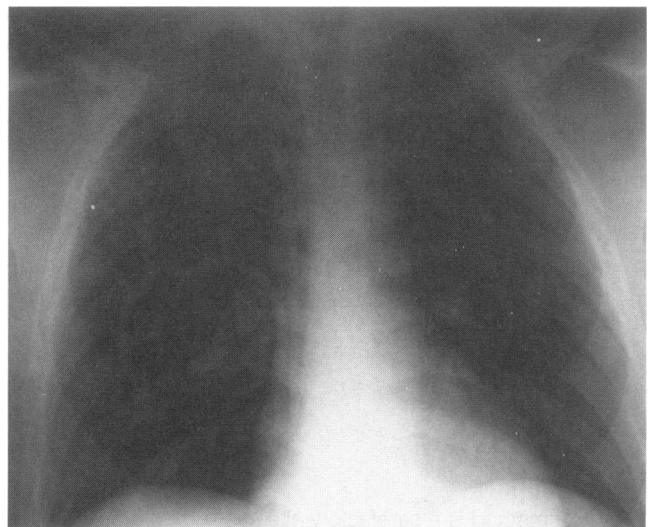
Optimal placement of catheter tip just inside the right atrium as seen on a postoperative portable chest x-ray.
